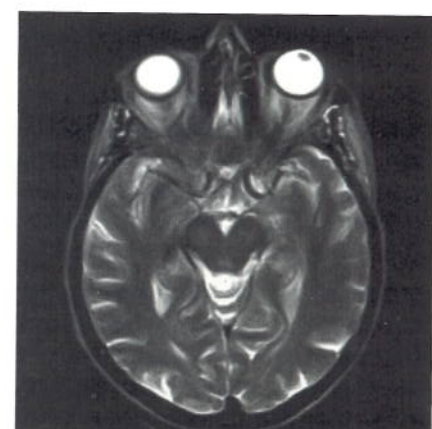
New dual echo TSE sequence for brains with flow compensation in both echoes, twenty 5mm slices in 6:30 min. Siemens exclusive in open MRI!
